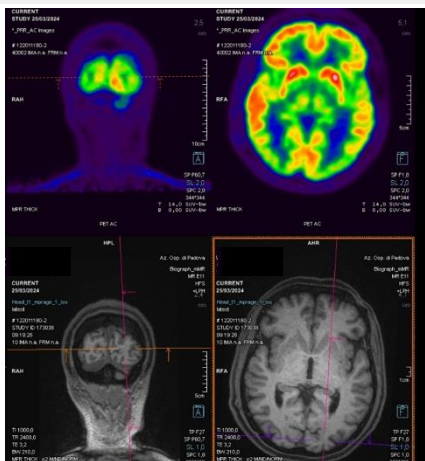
Brain PET-FDG/MRI. Note posterior bilateral parieto-occipital hypometabolism.
